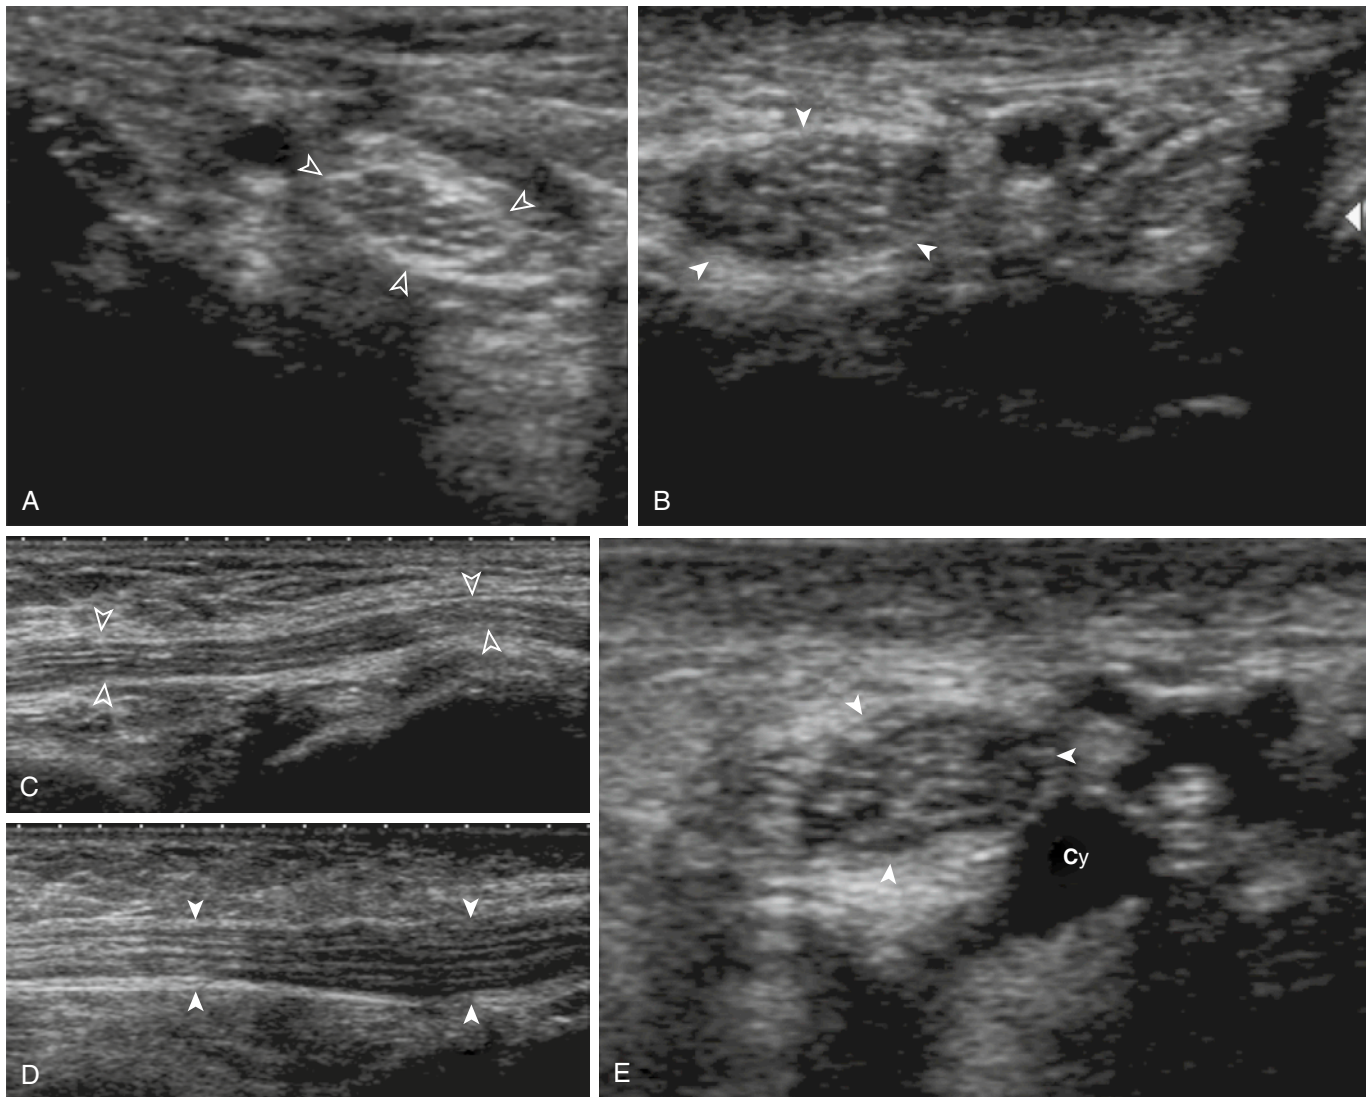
TARSAL TUNNEL SYNDROME. A woman had right plantar sole neuropathic pain and a small, palpable mass in the medial retromalleolar area. A, Short-axis, 5- to 14-MHz ultrasound image over the left normal tarsal tunnel shows a normal tibial nerve (*open arrowheads*). B, Short-axis, 5- to 14-MHz ultrasound image over the right tarsal tunnel shows a pathologically enlarged and hypoechoic tibial nerve (*closed arrowheads*) compared with the contralateral normal nerve (A). C and D, Corresponding long-axis ultrasound images of A and B show the same pathologic changes in D, compare to normal nerve in C. E, Short-axis, 5- to 14-MHz ultrasound image over the right tarsal tunnel in forceful dynamic dorsiflexion allows visualization of a subtalar cyst (Cy) compressing the tibial nerve (*closed arrowheads*) against the flexor retinaculum. This cyst was not visible in static scanning.
